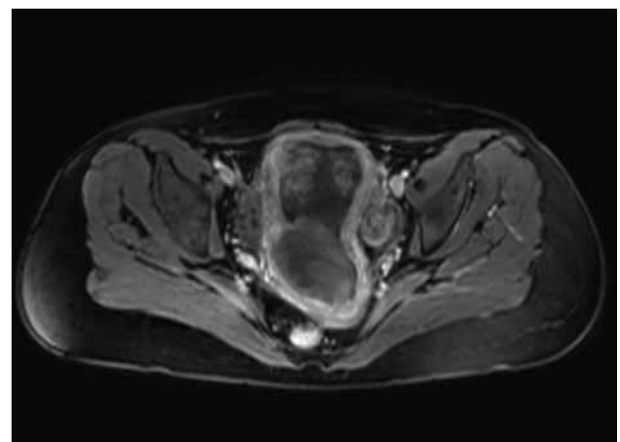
Magnetic resonance imaging of the lesser pelvis – cross section
